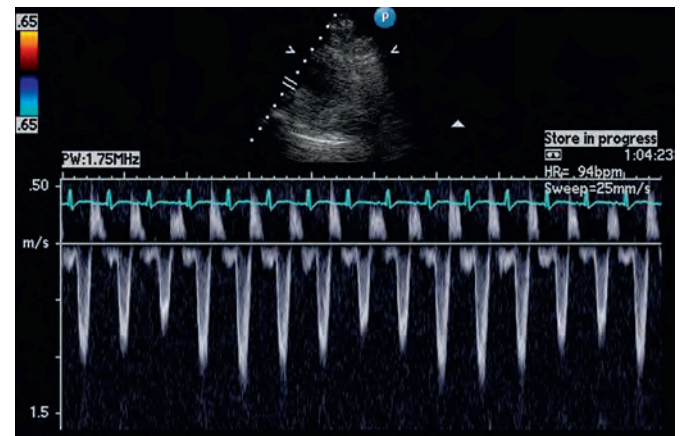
Pulsed-wave echocardiographic interrogation of the left ventricular outflow tract by using the deep transgastric view in a patient with tamponade physiology showing respiratory variability. HR, Heart rate.
